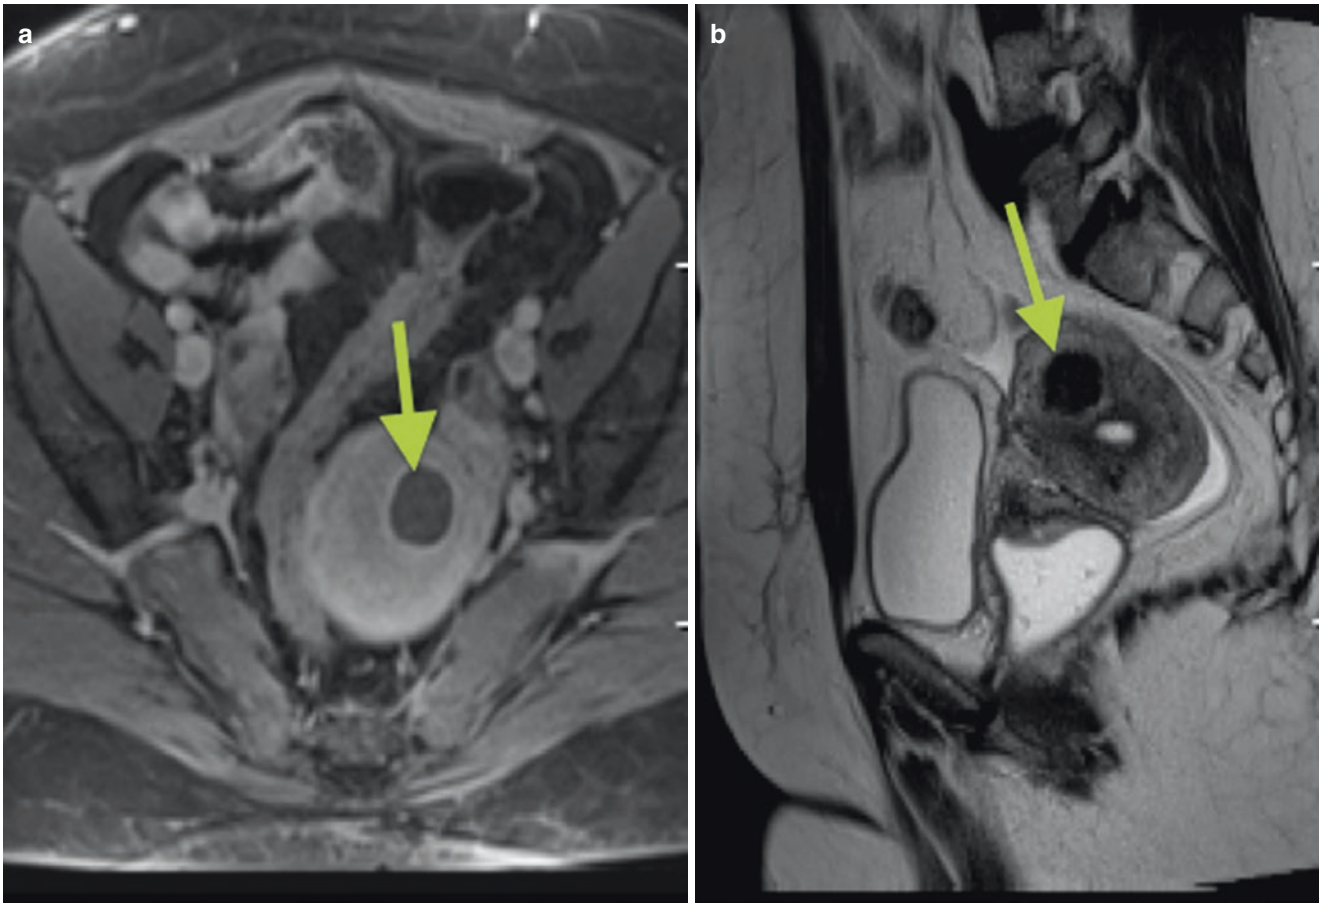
Calcified myoma: (a) MRI of the pelvis, axial, T1 weighted, in post-contrast, showing intramural uterine nodule (*arrow*) that is hypointense, with a hyperintense halo around it. (b) Same nodule, with sagittal image weighted in T2
